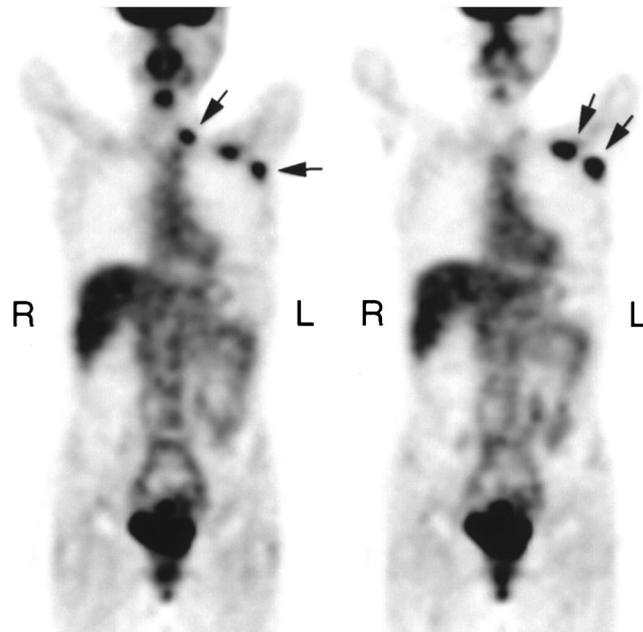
PET images of patient with recurrent breast cancer involving left axillary and supraclavicular lymph nodes (arrows). MRI has been interpreted as consistent with fibrosis after radiation. PET findings were verified by biopsy. Left and right panels depict more anterior and more posterior coronal views, respectively. (This research was originally published in JNM. Vranjesevic D, Filmont JE, Meta J, et al. Whole-body (18)F-FDG PET and conventional imaging for predicting outcome in previously treated breast cancer patients. *J Nucl Med.* 2002;43:325–329. © by the Society of Nuclear Medicine and Molecular Imaging [95]).
